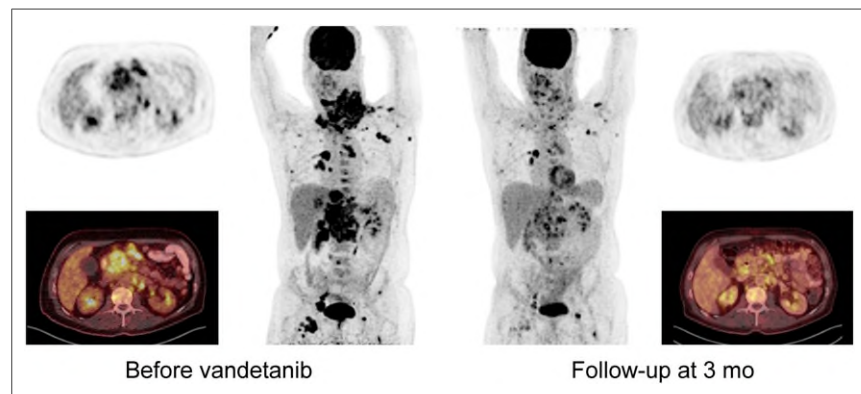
A 47-y-old man (patient 12) with extensive tumor load. Before TKI initiation, patient presented with highly aggressive disease on ^{18}F -FDG PET, with SUV_{mean} of 13.4 for hottest lesion (right clavicular lymph node). After 3 mo of vandetanib, partial response could be detected, with 54.5% decline in metabolic activity (SUV_{mean} , 6.1). However, because of disease aggressiveness, patient died 11 mo after start of treatment.
